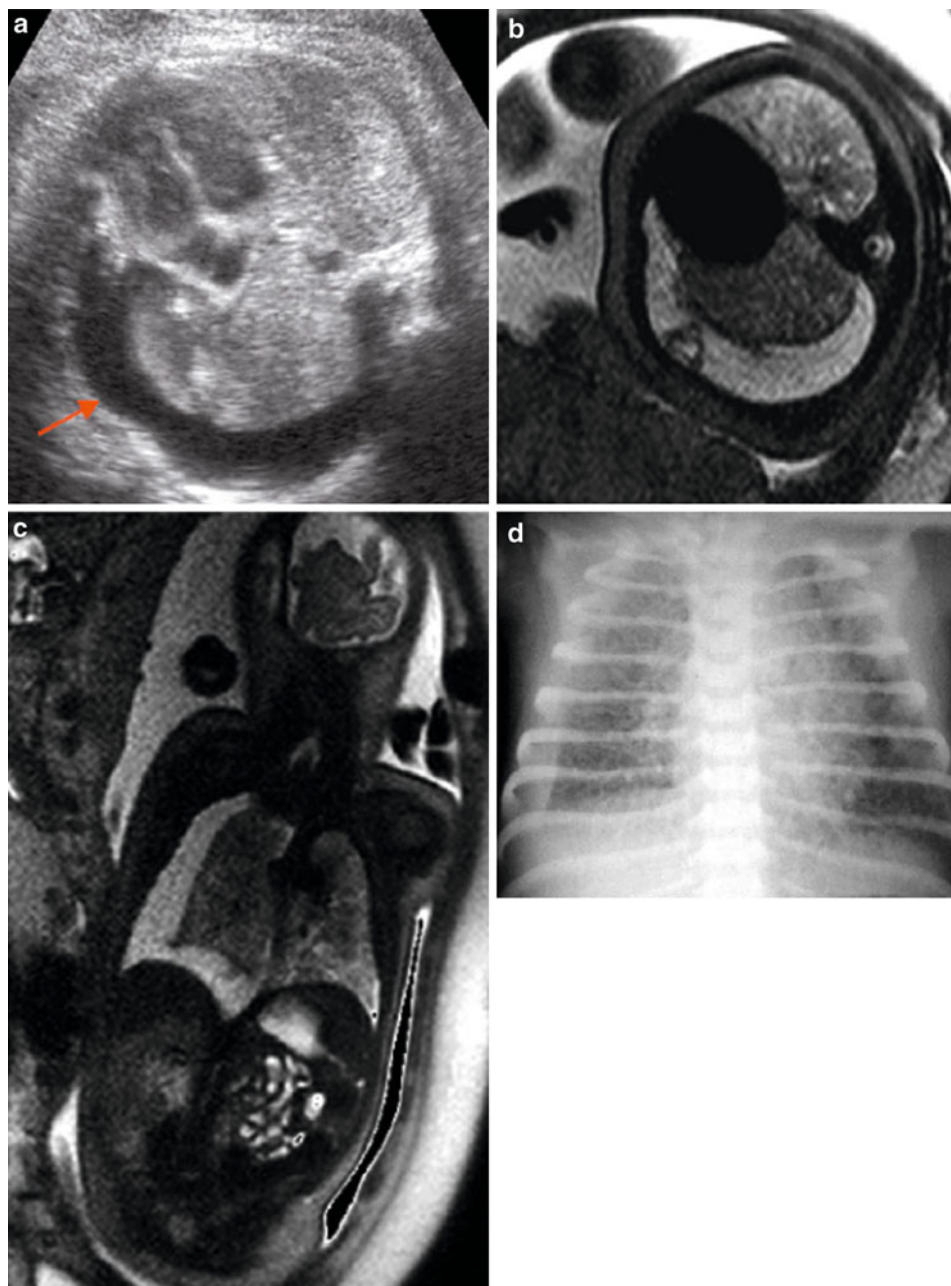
Neuroenteric cyst. a Ultrasound view of the spine shows an associated segmental anomaly (*arrow*). b Sagittal T2-weighted image showing the cyst close to the spine. Note the dilated bowel loop (\*)
